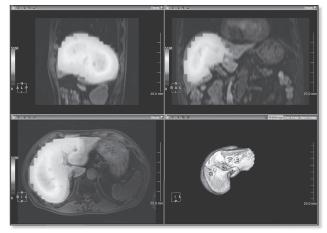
Liver Fusion by Virtual Place; The images were acquired by SPECT and MRI.
